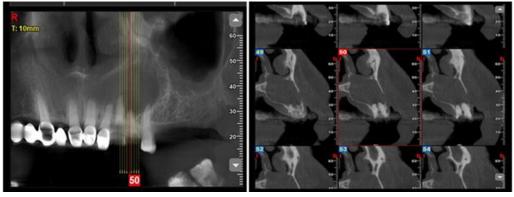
(Pre-operative CBCT images.)
